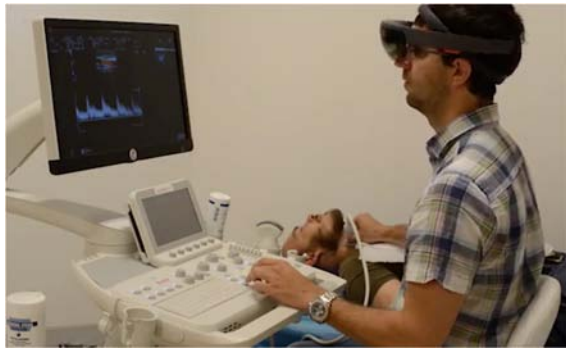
Learner is ‘wearing’ an expert’s experience, performing an ultrasound diagnosis with the *player* application
